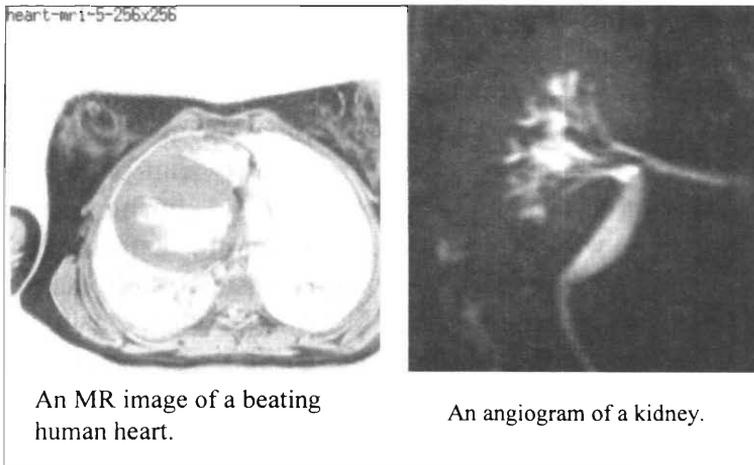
MR image of the heart in a patient with hypertrophic cardiomyopathy (i.e a very thick heart muscle), and an angiogram of a kidney after a catheter has been placed in the renal artery. The images were obtained using cardiac gating.
